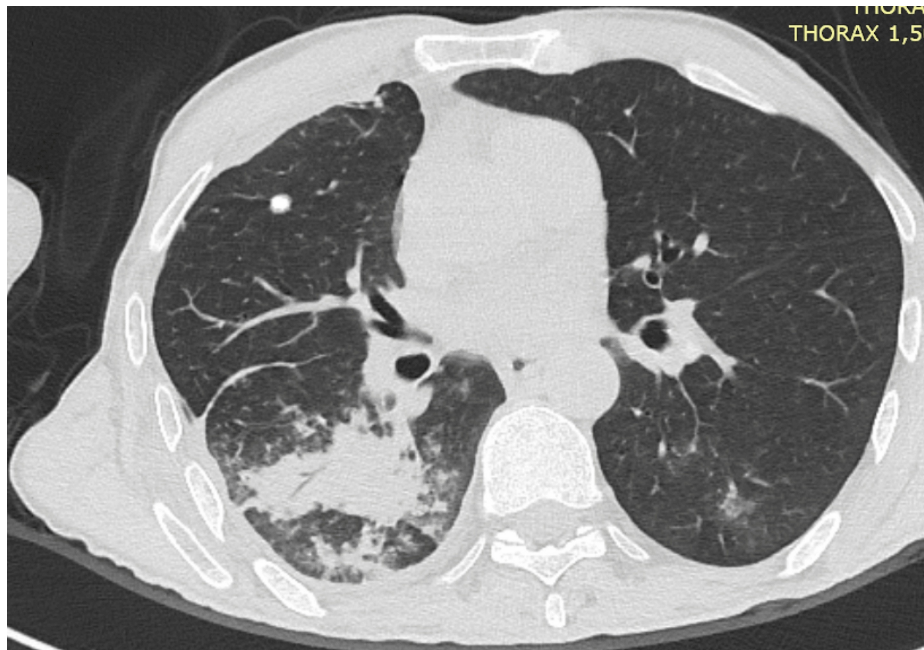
Axial chest CT scan at three months. Right lower lobe parenchymal consolidation with posterior-basal predominance and associated air bronchograms. A calcified right pulmonary nodule, consistent with a residual granulomatous lesion, is also visible.
